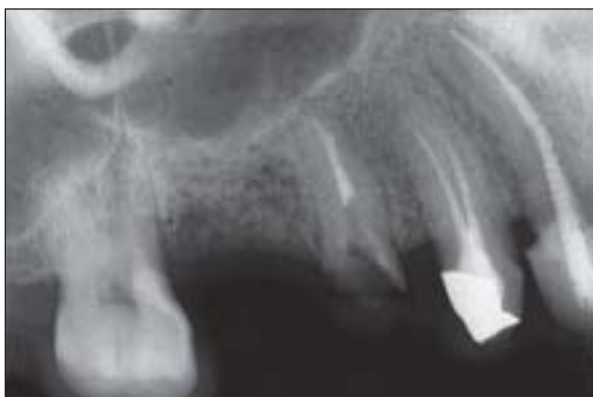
A preoperative periapical radiograph of the patient shows sufficient bone height for the OSFE procedure and immediate implant placement in the area of the maxillary right first molar.
